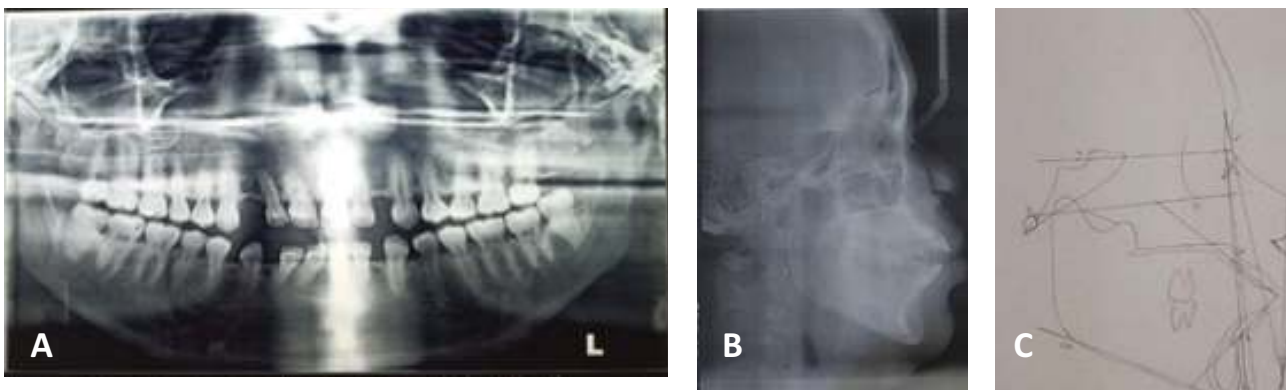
(A) Initial panoramic radiograph, (B) Initial lateral cephalometric radiograph, and (C) tracing
